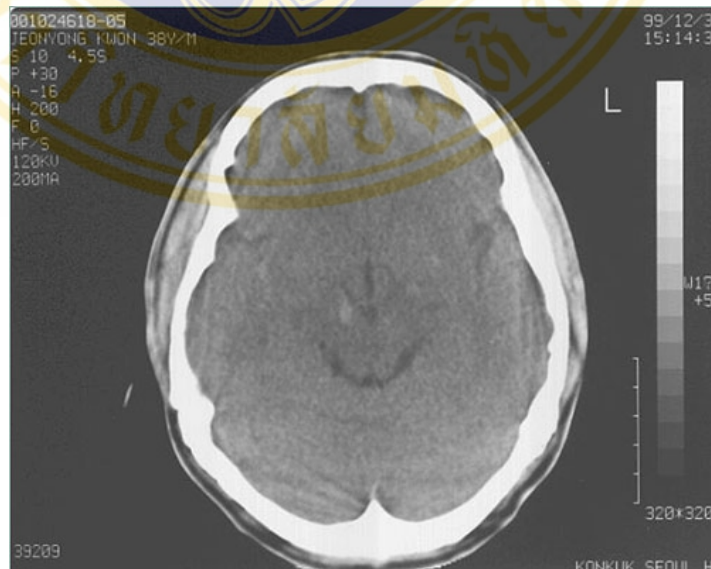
of patients with DAI, 80% demonstrate multiple hemorrhages areas of injury on CT. Note that the hemorrhages are characteristically located at the gray-white matter interface.
